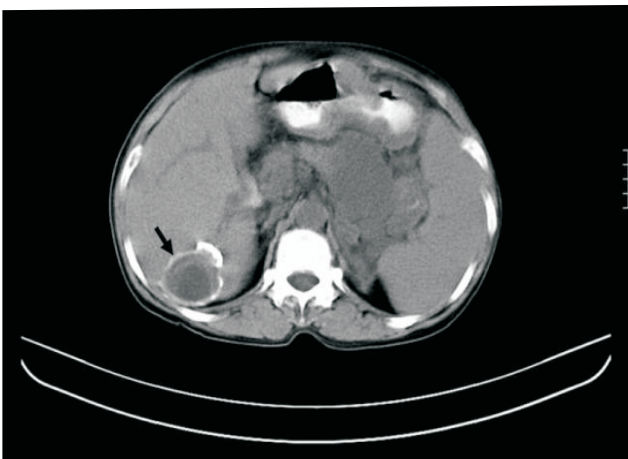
CT scan showing a hypochoic lesion in the liver
